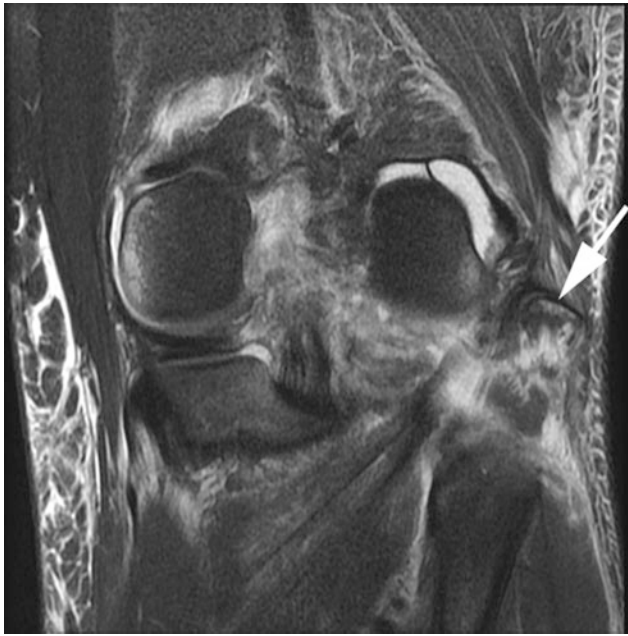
A right knee is visualized using magnetic resonance imaging to demonstrate an arcuate fracture of the fibular head (arrow)
